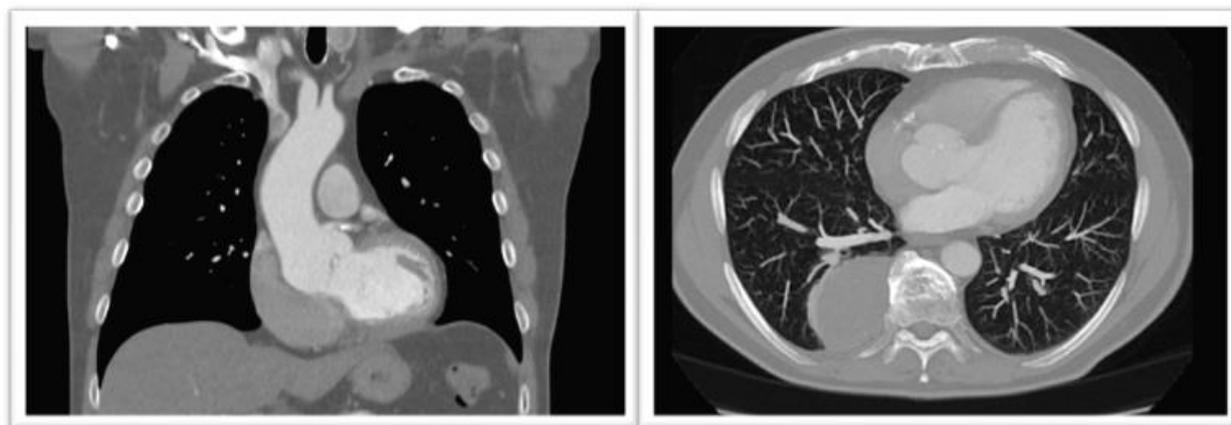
Contrast-enhanced computed tomography (CT) of the chest demonstrating dilated aortic root and significantly larger non-coronary sinus of Valsalva compared to the other sinuses
